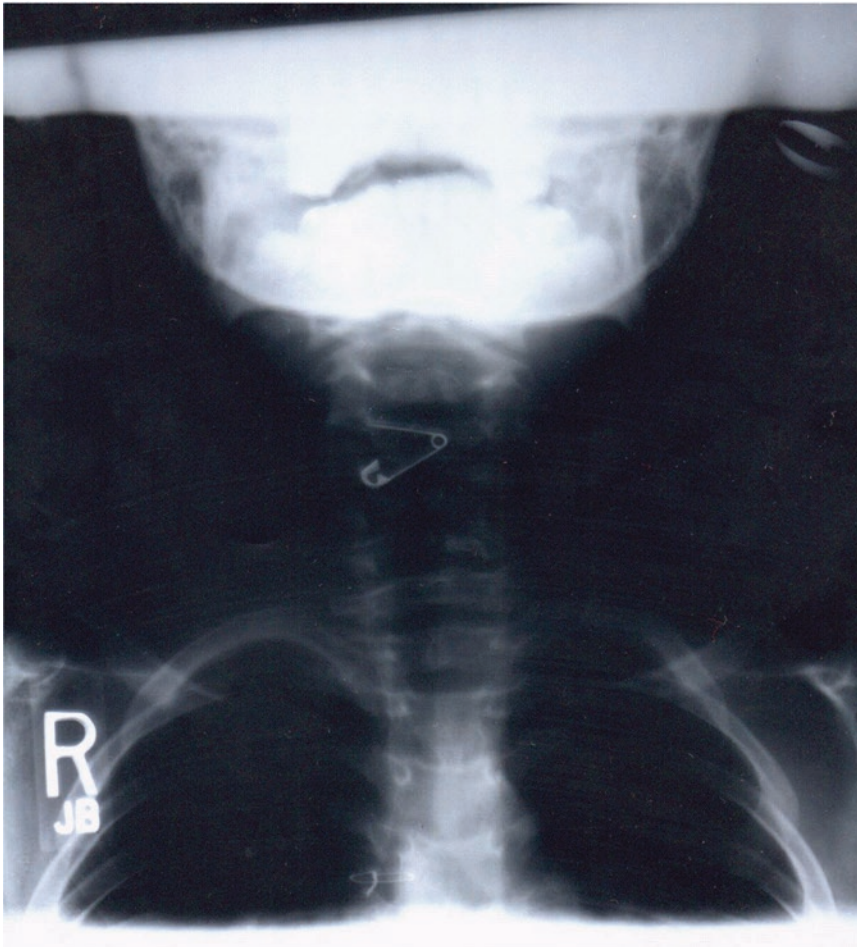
X-ray showing physical evidence of the severity of participant's pica in Falcomata et al., (2007; Reprinted with permission from Roane et al. (2005)). The X-ray also appeared in Falcomata et al. (2007).
